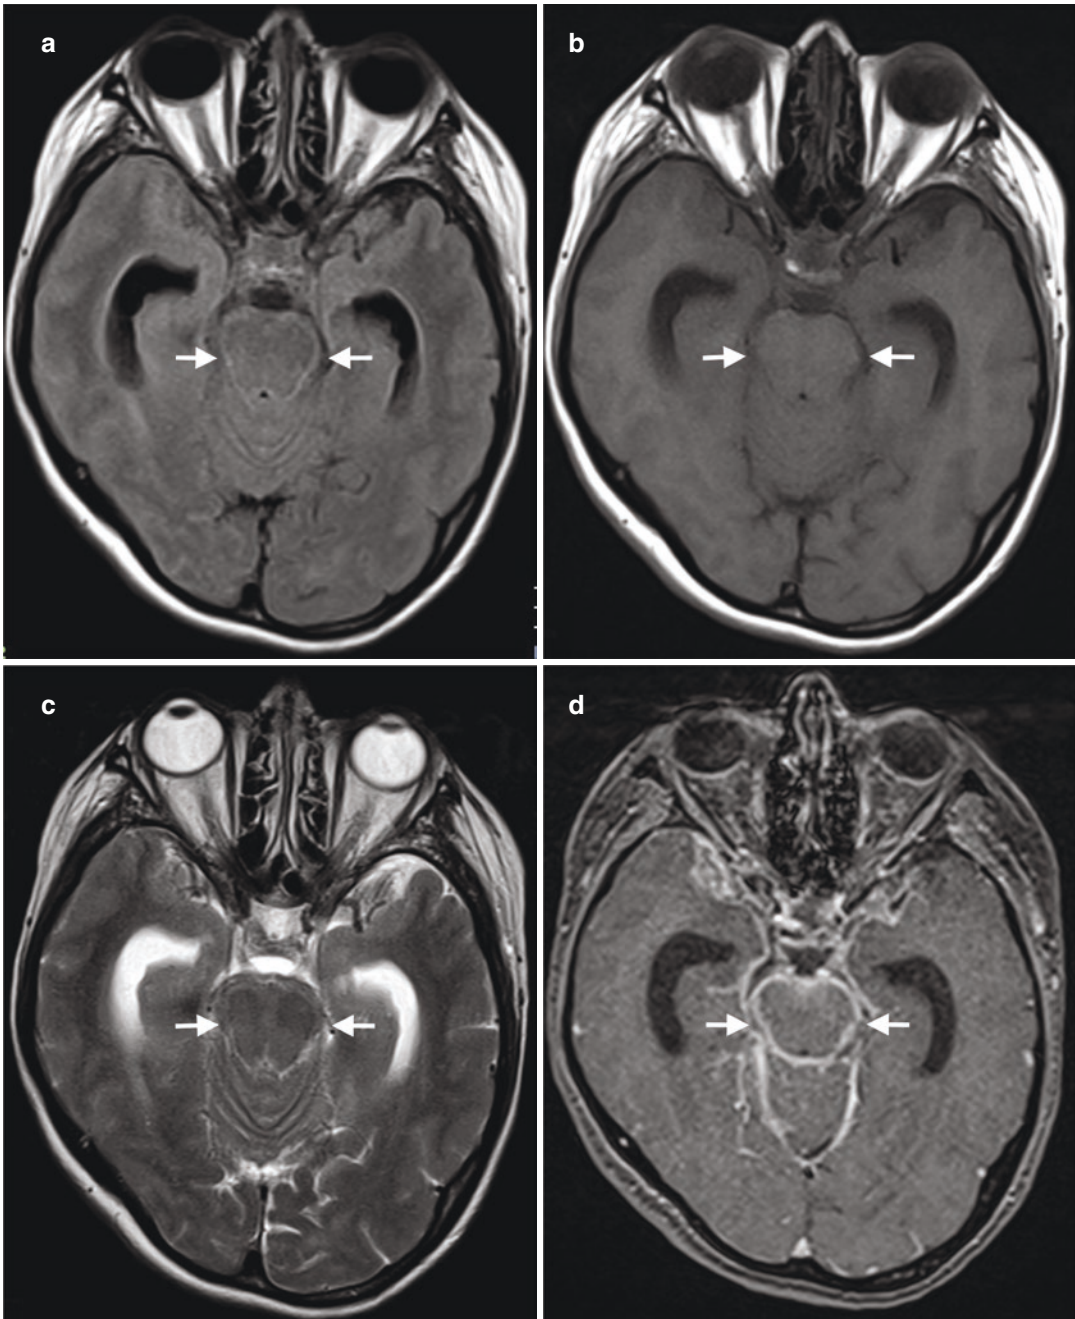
Leptomenigeal tuberculosis. (a) Axial FLAIR MR image shows abnormal hyperintense signal outlining the pons (arrows). Suppression of CSF signal in FLAIR sequences accentuates this area of leptomenigeal abnormality, which would otherwise be difficult to detect on
